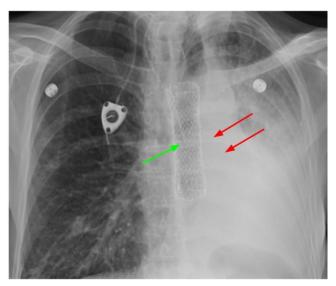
PA chest radiograph shows the esophageal stent (green arrow) and interval loss of visualization of the normally air filled left mainstem bronchus (red arrows). There is associated new left side pulmonary volume loss and new left sided consolidative pulmonary opacities.
